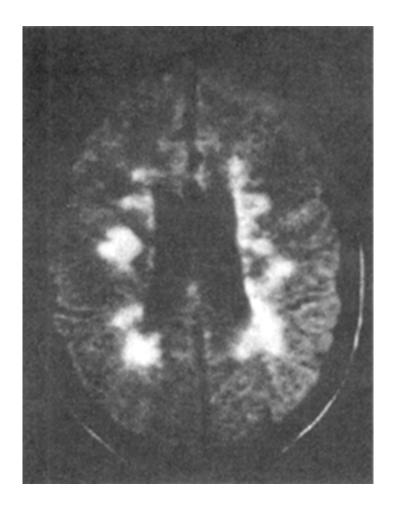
MRI study of the head. Extensive confluent periventricular lesions are seen in a patient with multiple sclerosis. The corresponding CT scan was normal. (Reprinted with permission from Lukes SA, Crooks LE, Aminoff MJ, Kaufman L, Panitch HS, Mills C, Norman D: Nuclear magnetic resonance imaging in multiple sclerosis. Ann Neurol *13*:596, 1983.)
